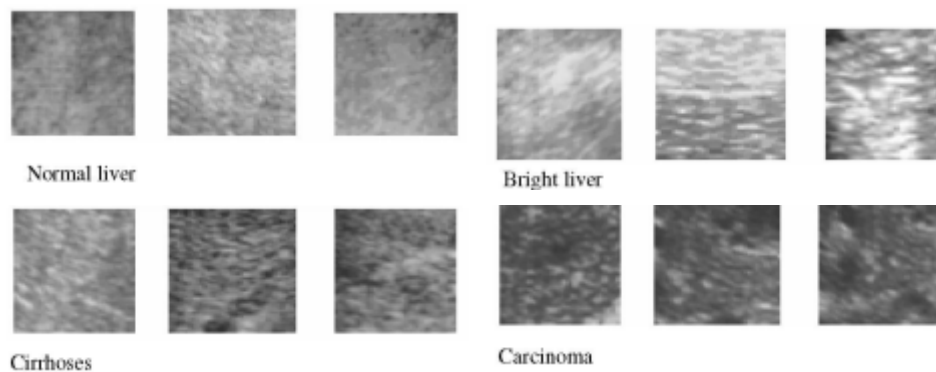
Ultrasound image samples for liver cases.
